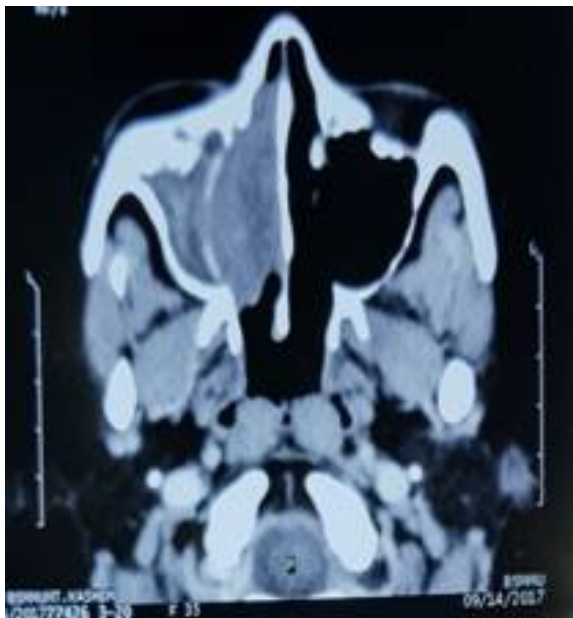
CT scan of paranasal sinuses shows large infiltrative mass of ethmoid sinuses
